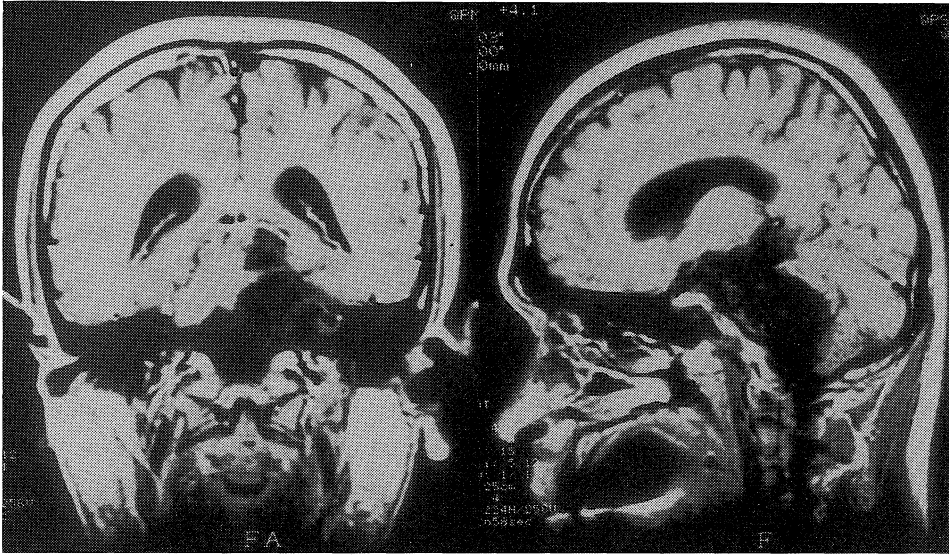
Coronal and sagittal image of MRI demonstrating extension of the tumor from the ventral side of the medullae into the parasellar region.
